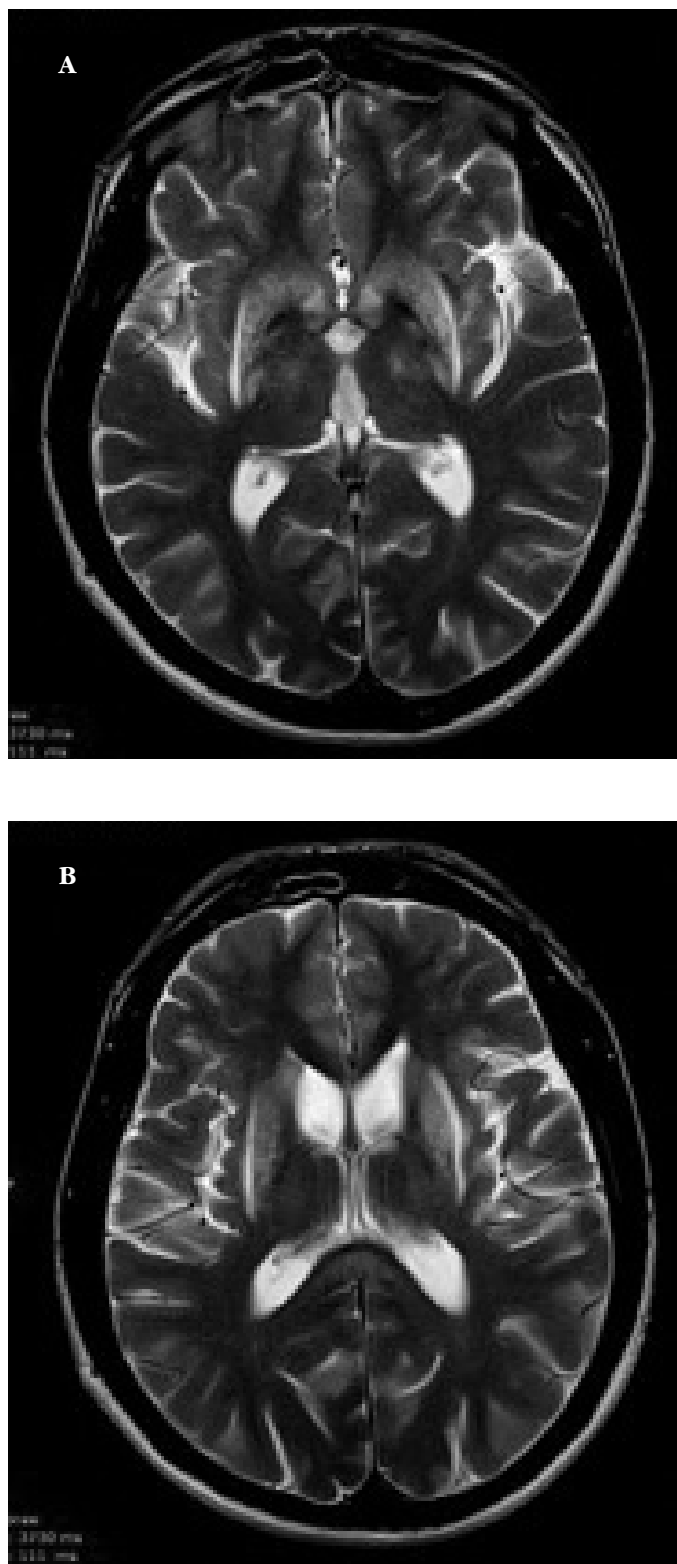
a-b: Signal changes on caudate nucleus and putamen seen in the T2 weighted cranial MRI of a Wilson's disease patient.
